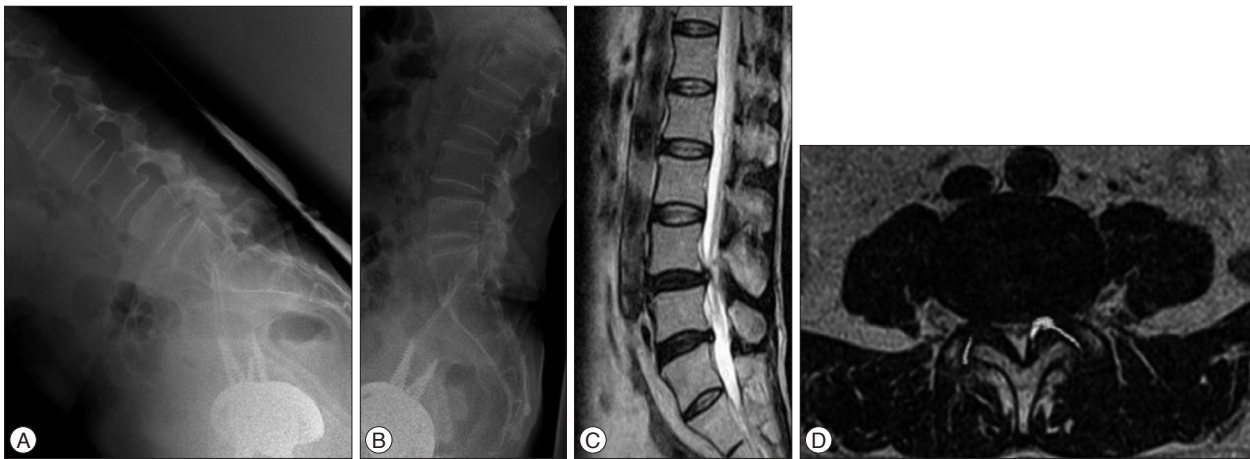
A and B : Simple dyanmic flexion and extension views show mild instability at the L3–4 level. C and D : T2-weighted magnetic resonance images showing cyst on the left L3–4 facet joint and compression of the L5 root.
